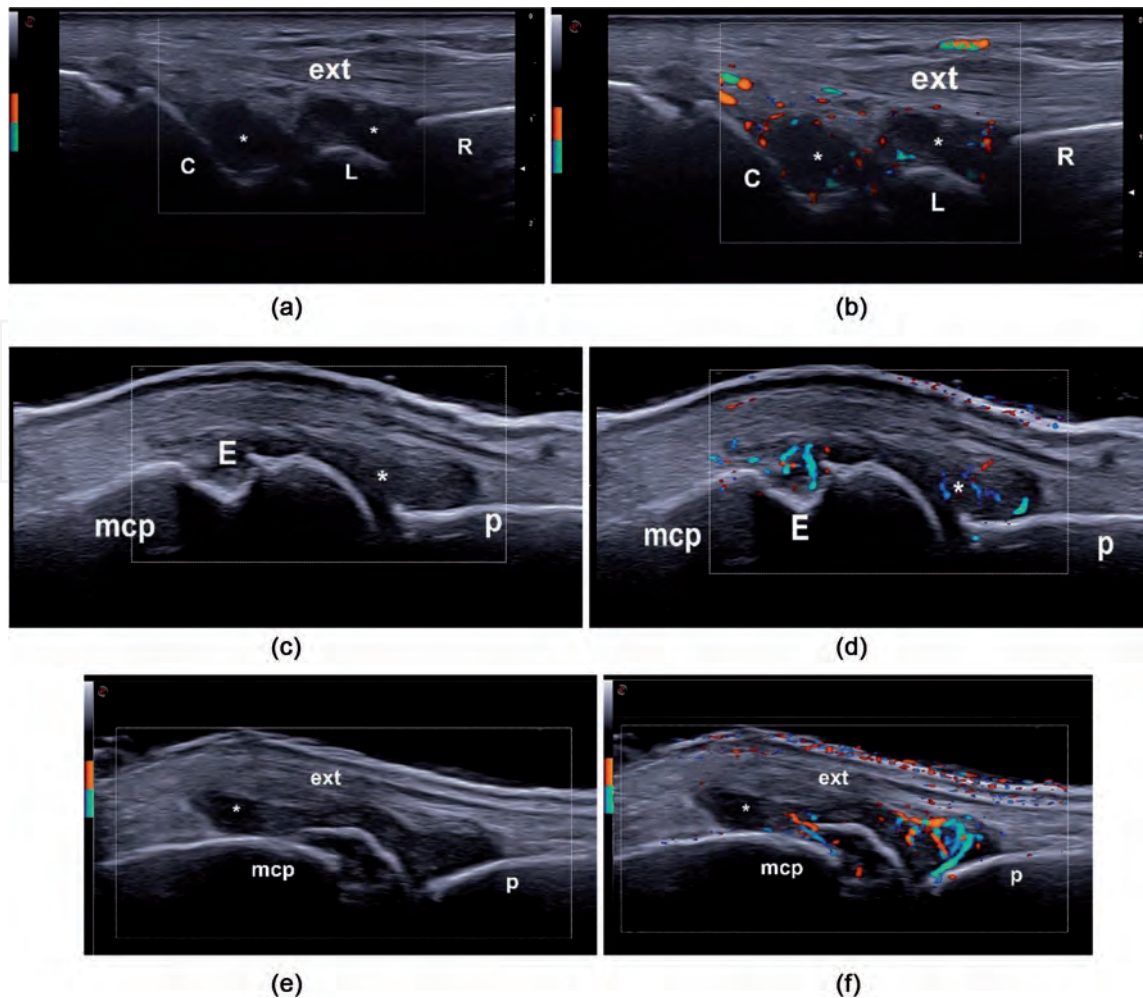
Synovitis in GS (left images) and with power Doppler (right images) at the level of the wrist (a) and metacarpophalangeal joints (c-f). e – Erosions, ext. – Extensor tendons, mcp - metacarpal bone, p – Phalanx, asterisk – Synovitis.
